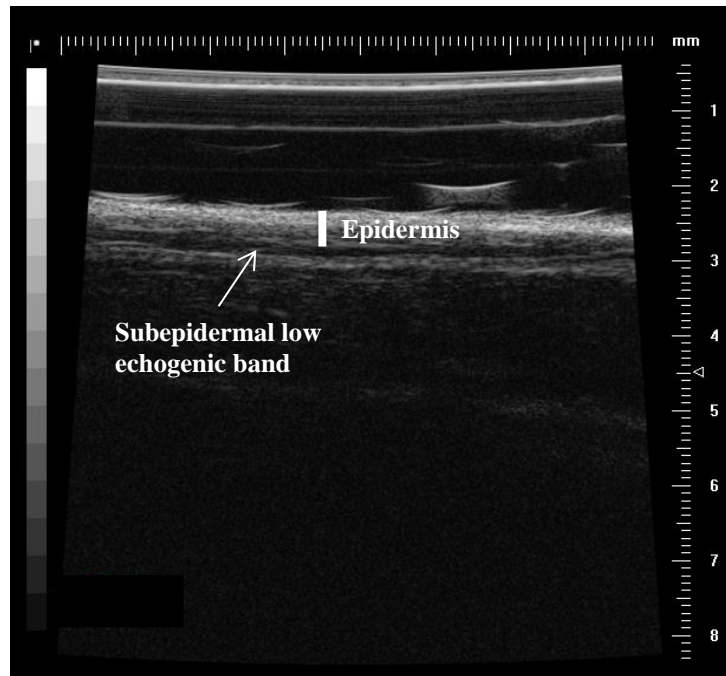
Ultrasound image showing the epidermal and subepidermal low echogenic band thickness at the first metatarsal head of a healthy subject.
